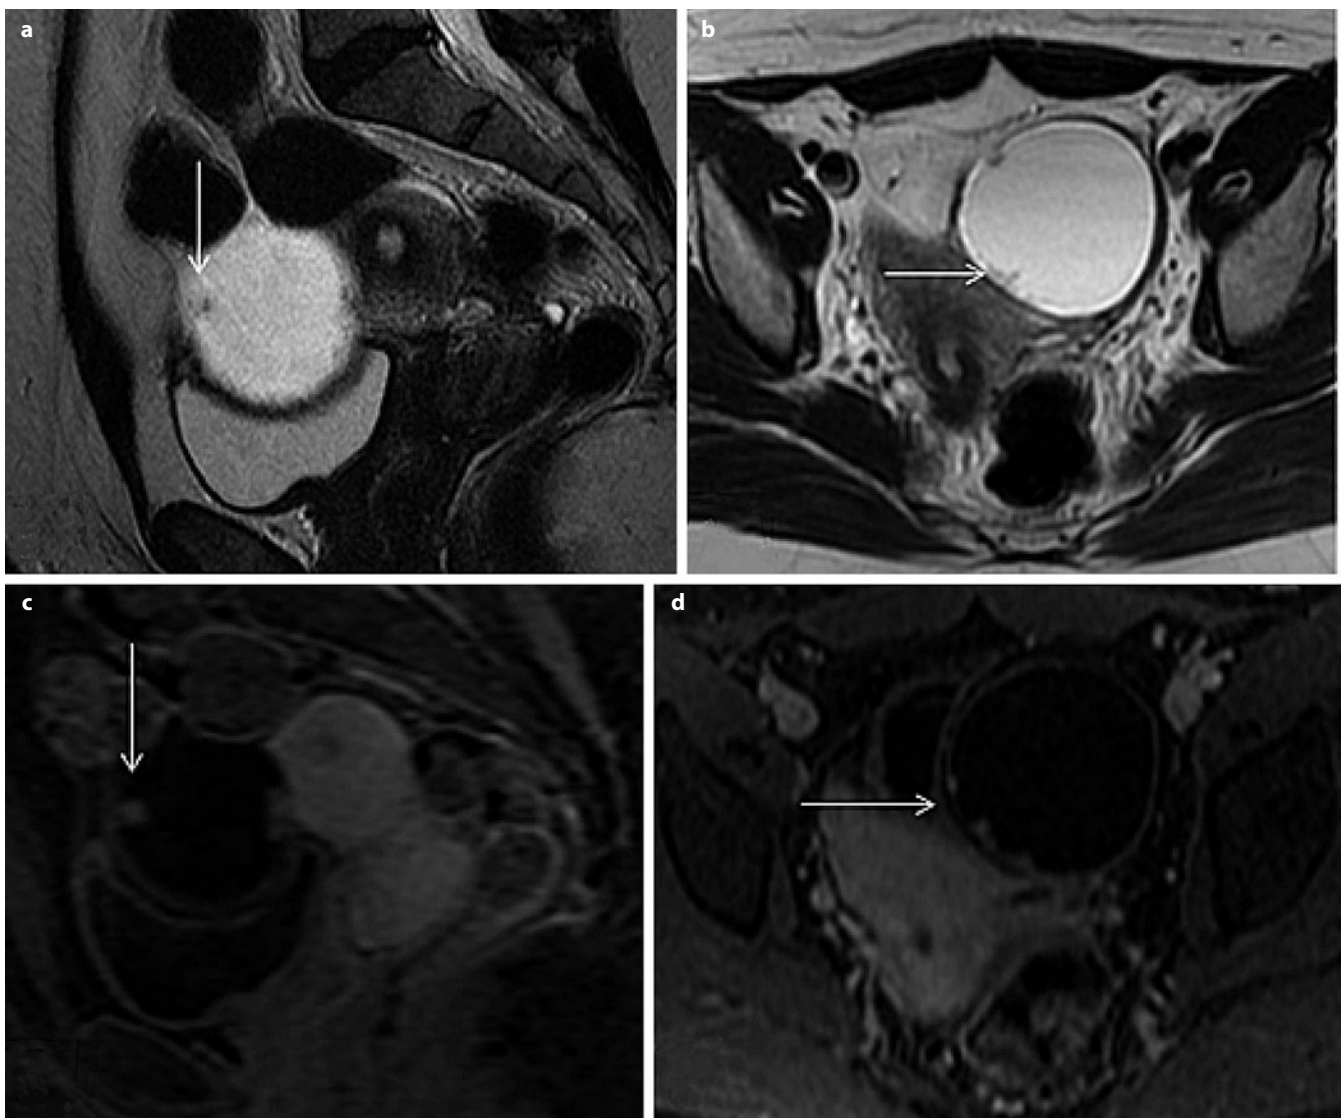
a-d. Serous borderline ovarian tumor. a Sagittal and b axial fast-spin-echo T2-weighted image (FSE T2-WI) show unilocular, thin-walled cystic lesion, with intermediate signal intensity T2 papillary projections (*arrows* in a and b). c, d Sagittal and axial gadolinium-enhanced fat-saturated (FS) T1-WI confirm the presence of solid papillary projections, characterized by contrast enhancement
